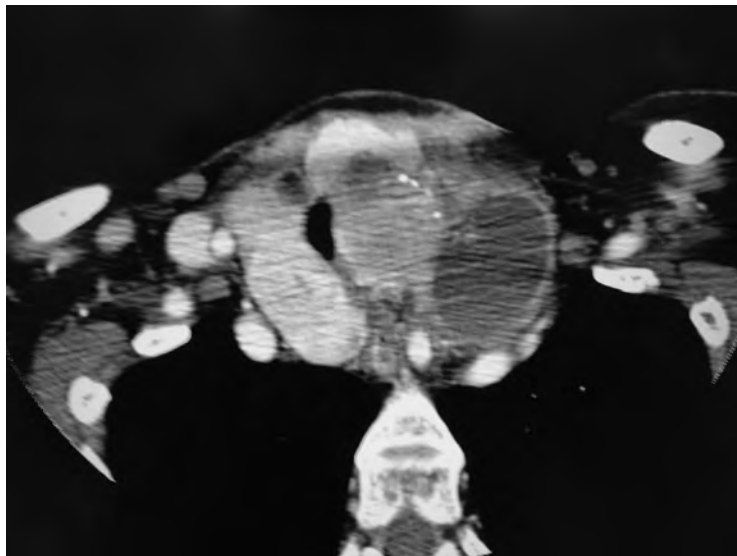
An axial view of a contrast-enhanced computed tomography scan of the neck showing a massive goiter with calcification.
